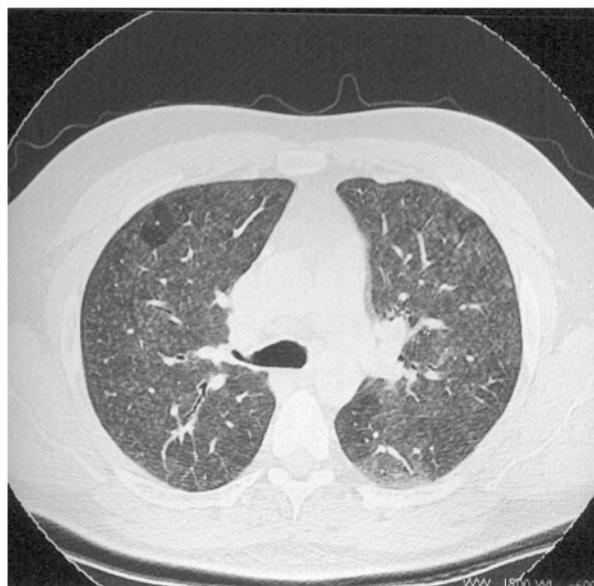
CT scan of the chest in a patient with BOOP following anthrax vaccination demonstrated a mosaic pattern with nodular-appearing ground-glass opacities that were accentuated in the upper lobes.
